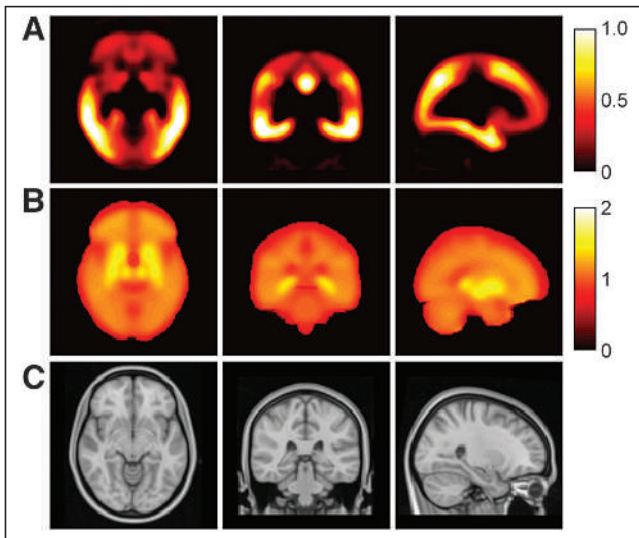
Canonical images for ¹⁸F-flortaucipir PET derived from spatiotemporal modeling of chronological AD data in MNI152 space: tau canonical image (K) (A), nonspecific canonical image (NS) (B), and reference structural T1-weighted MR image (C).
